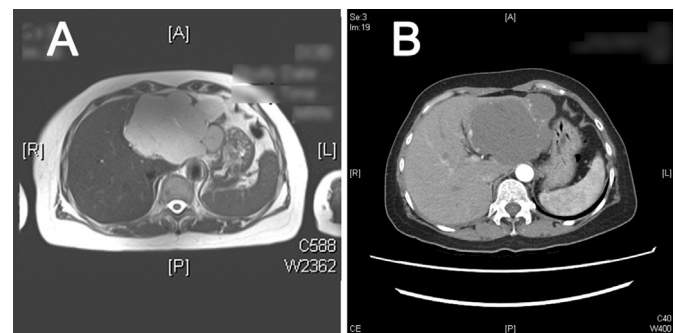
(A) Preoperative magnetic resonance imaging (MRI) shows a lobulated high-intensity-signal tumor in the left lobe of the liver. (B) Follow-up postoperative computed tomography (CT) scan confirms hepatic cavernous hemangioma with early peripheral puddling and gradual centripetal perfusion.
